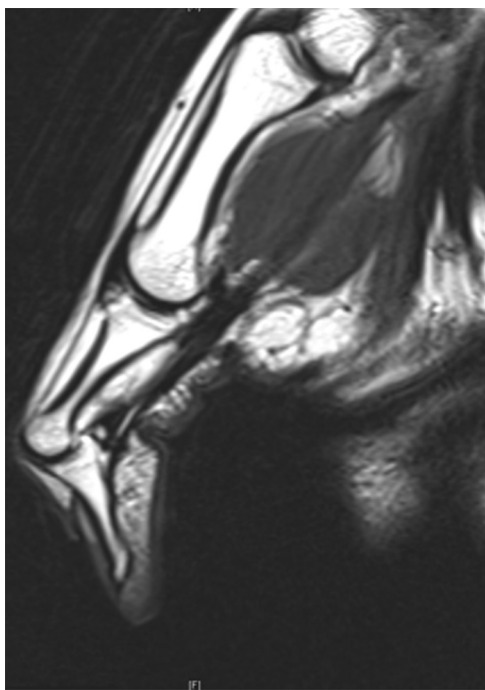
Preoperative magnetic resonance imaging. Bowstringing is apparent during interphalangeal joint flexion, with disruption/absence of the oblique, A1 and A2 pulleys.
